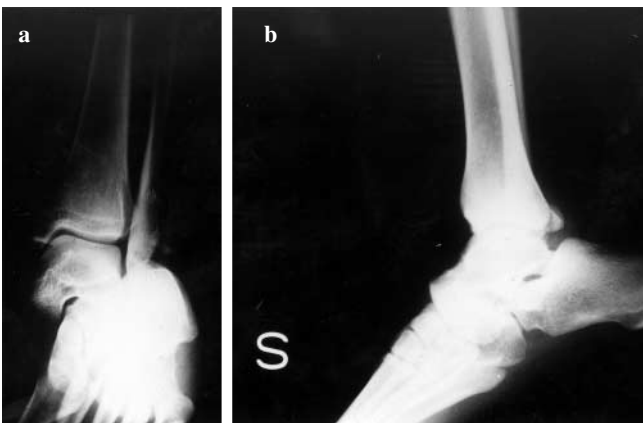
Case 1. Anteroposterior (a) and lateral (b) radiographic views of a lateral subtalar dislocation with parcellar fracture of peroneal malleolus
